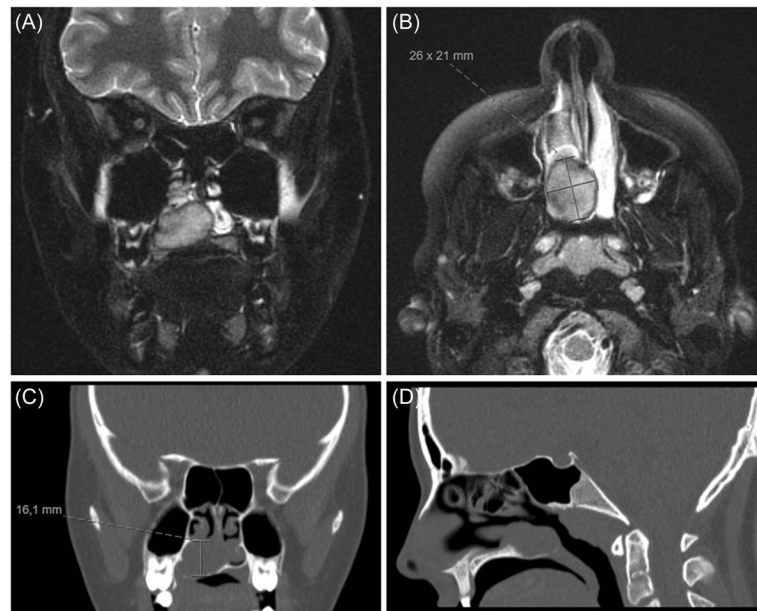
Preoperative MRI and CT imaging. (A) Coronal view of a T2 weighted MRI scan showing a solid tumor of the right-sided inferior turbinate with expansion to and thinning of the hard palate and expulsion of the nasal septum; (B) transversal view of a T2 weighted MRI scan showing a tumor extension of 26 × 21 mm; (C) coronal view of a CT scan with signs of locally expansive tumor growth; and (D) sagittal reconstruction of a CT scan showing a markedly thinning of the bone of the hard palate. CT, computed tomography; MRI, magnetic resonance imaging.
